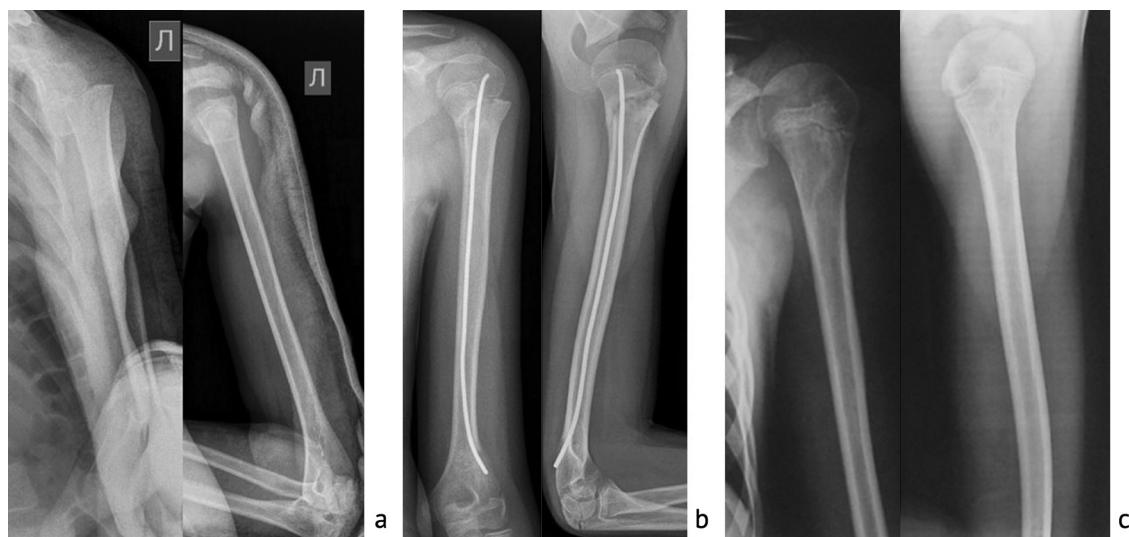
Patient's radiographs: (a) at admission; (b) one months after surgery; c 12 months after surgery
